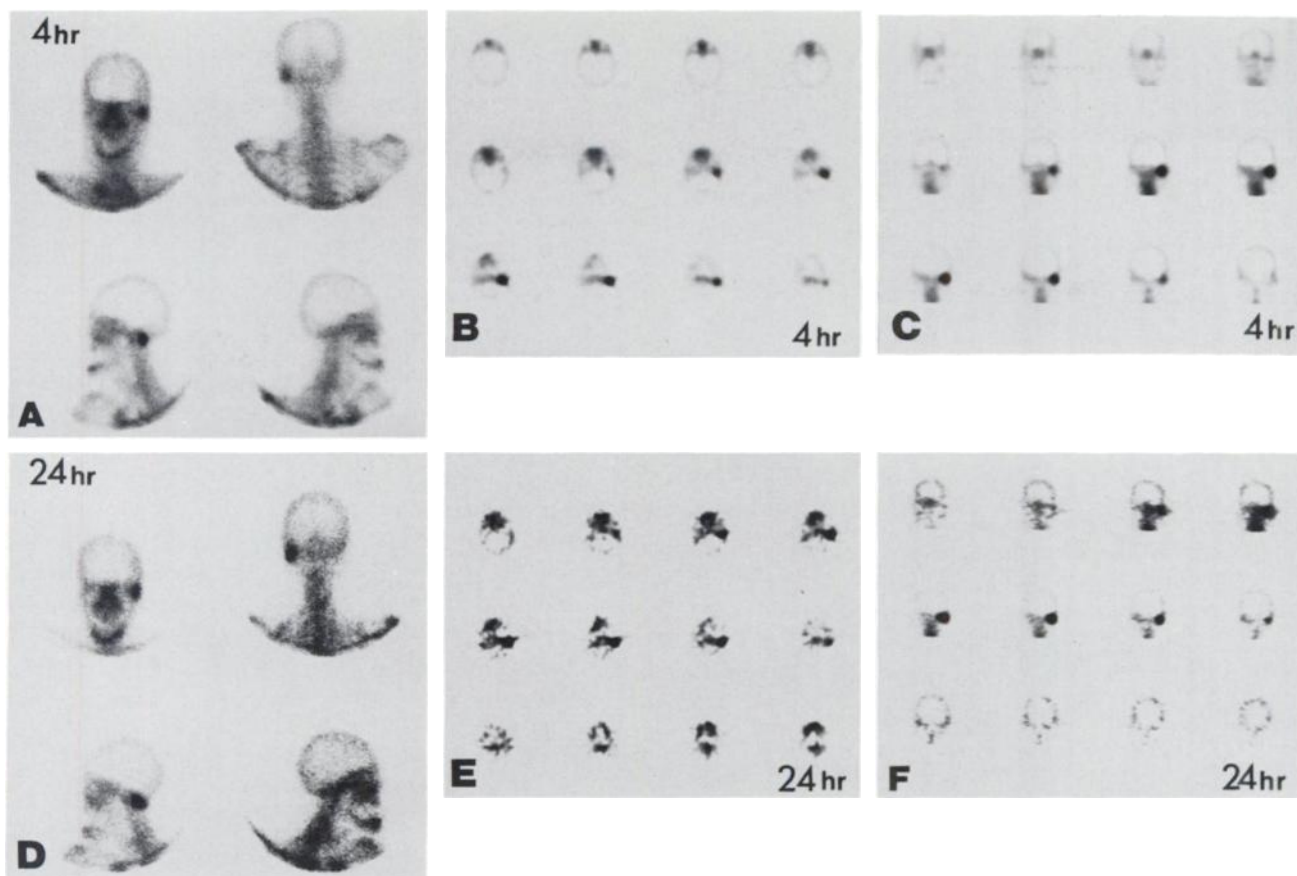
Four- and 24-hour planar and SPECT images of a 66-yr-old diabetic male patient with NEO (same patient as in Fig. 1). The patient presented with a painful left ear and pus discharge which was unsuccessfully treated for 3 wk with ciprofloxacin. On admission, severe edema and granulation tissue were observed and culture yielded *Pseudomonas*. Computed tomography of the skull was normal. Planar 4-hr (A) and 24-hr (D) bone scintigraphy showed increased uptake in the left temporal bone with L/N of 3.8 and 4.06, respectively and a 24/4-hr count ratio of 1.06. Four- and 24-hr transaxial (B, E) and coronal slices (C, F) generated from the SPECT studies. The highest L/N count ratios were found on the coronal slices: 4 hr: 3.8; 24 hr: 4.4; 24/4: 1.15. The patient required four local debridement procedures and prolonged intravenous administration of antibiotic therapy.
